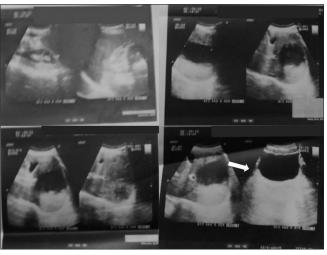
Ultrasonography- whole abdomen (11 August, 2020): showed liver normal in size with resolving abscess
